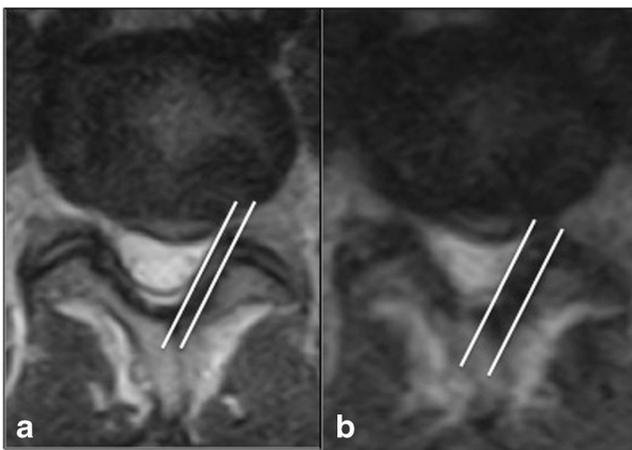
Axial T2-weighted TSE in supine (a) and upright (b) standing. Flavum ligament thickening at L4-L5 level is increased in b, especially at left (white lines)
